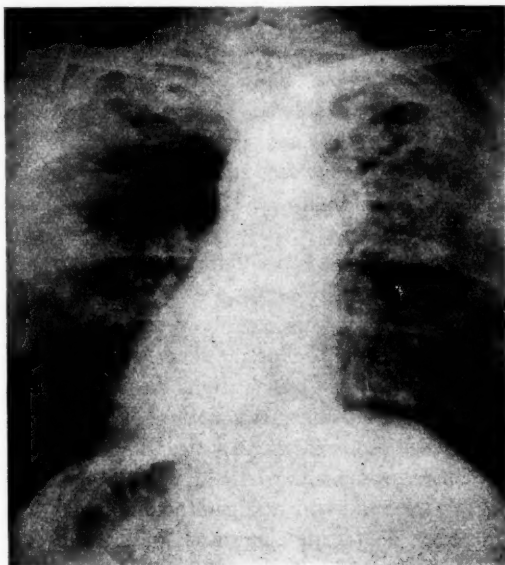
Chest radiograph of Case I. Advanced pulmonary tuberculosis developing in a diabetic while the patient was under observation.
